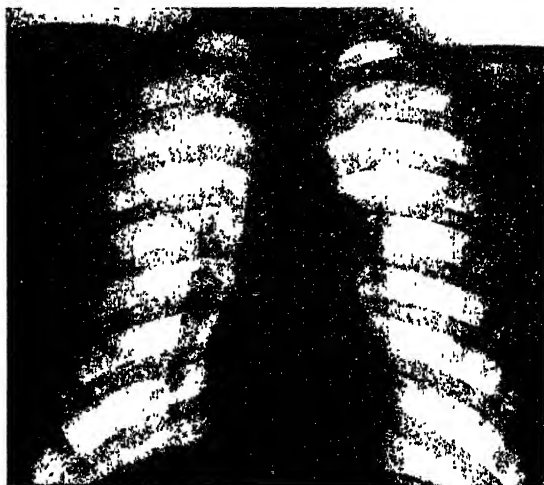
Radiograph of patent ductus arteriosus, showing typical dilatation of pulmonary artery. (From *Archives of Disease in Childhood*, 1932)
